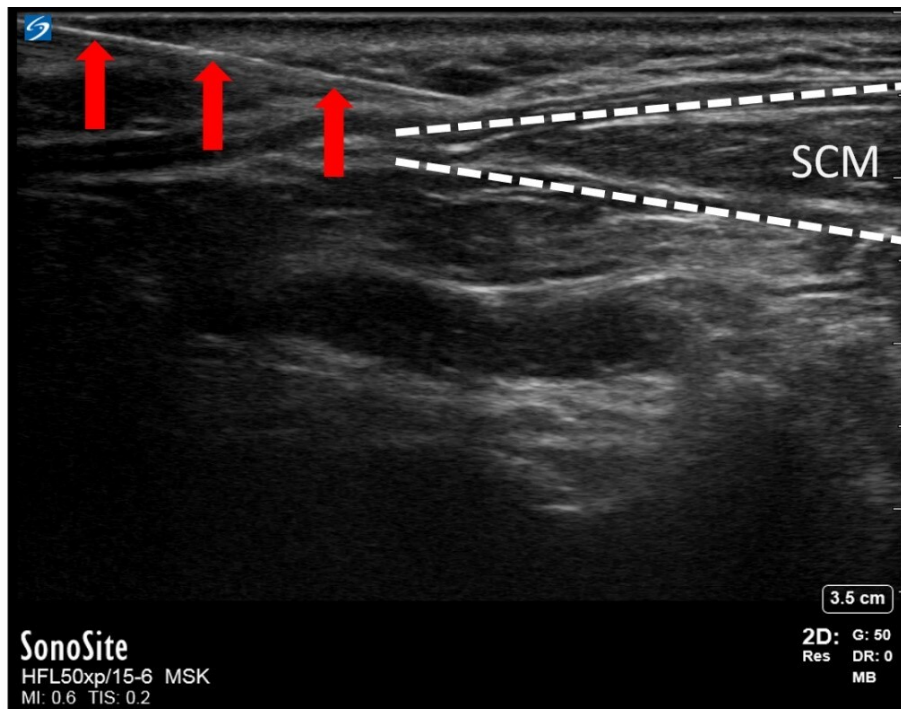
Ultrasound guided needle (red arrows) placement, SCM outlined in white
